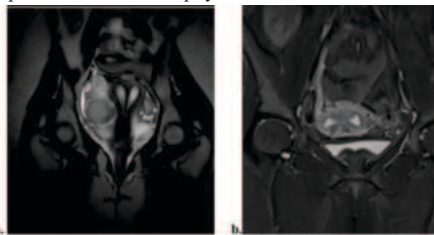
T2w fat sat coronal(a) and axial (b) MRI image demonstrating complete septate uterus.
